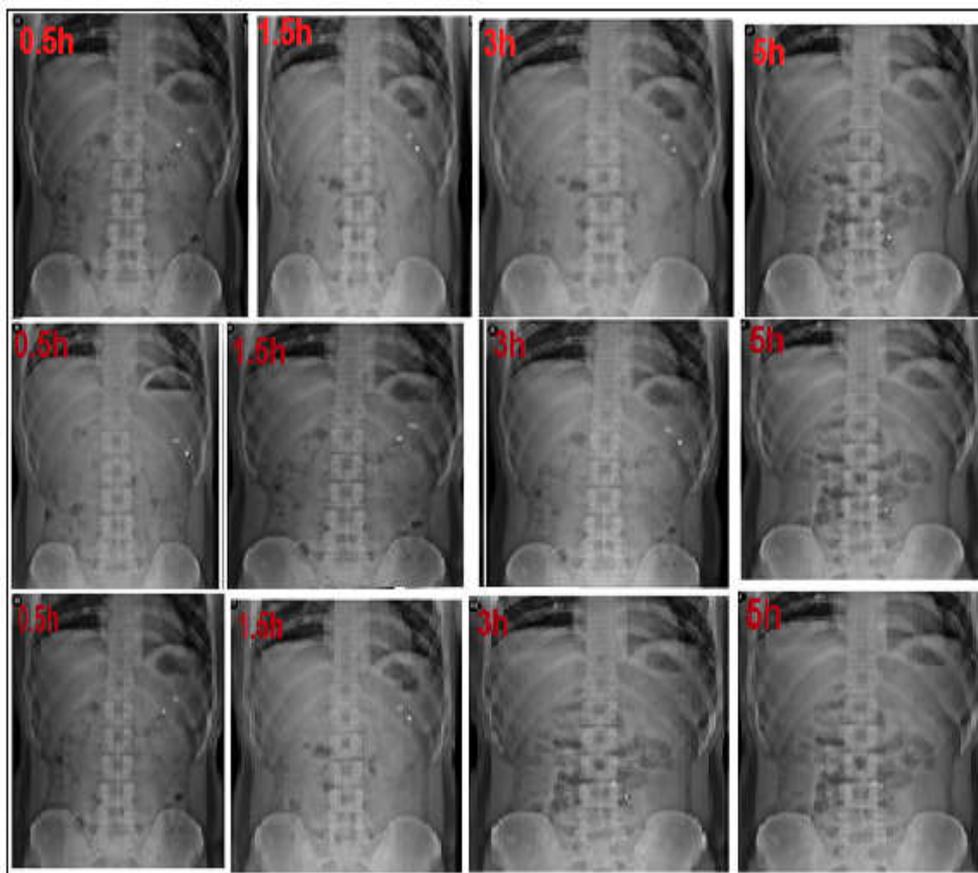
Radiographic images of BaSO₄-loaded baclofen floating-bioadhesive tablets in the stomach at different time intervals of 0.5 h, 1.5 h, 3 h and 5 h (mean \pm SD, n=3)
